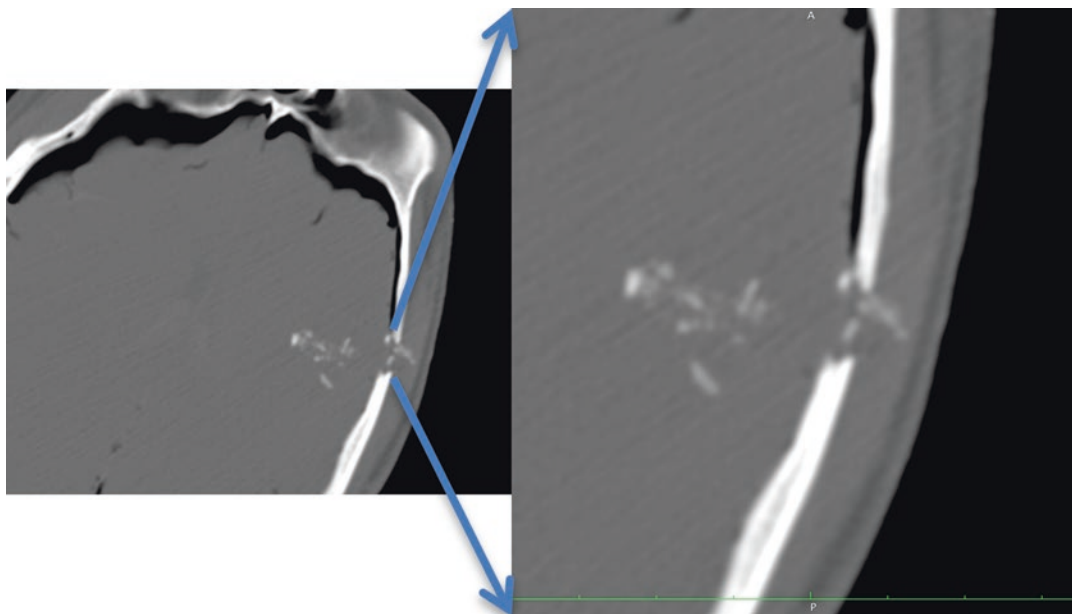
Axial CT image, filtered with bone window, of a gunshot-wounded skull with the magnification of the inlet orifice, showing the typical truncated cone shape
